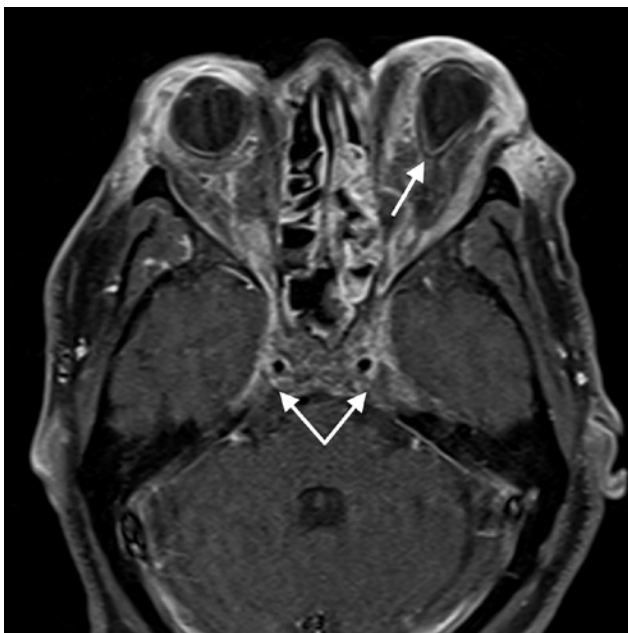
Axial T1-weighted magnetic resonance image of the orbits and head on day 5, demonstrating a bilateral cavernous sinus thrombosis (bottom arrows), as demonstrated by the lack of normal enhancement in the cavernous sinus and tenting of the left globe (top arrow), which is suggestive of increased orbital tension.
